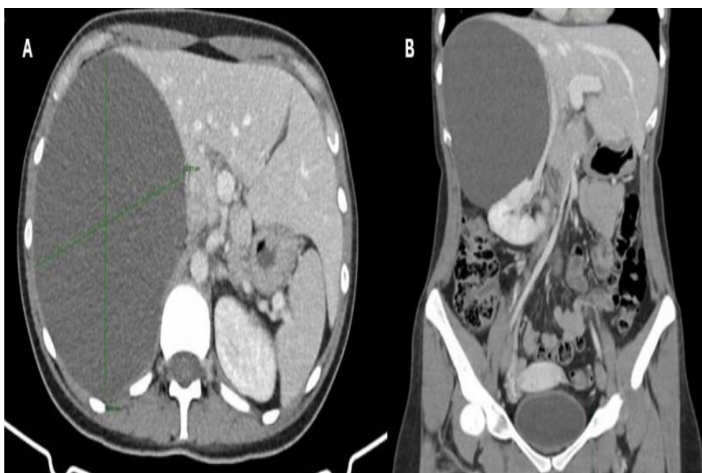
Abdominal CT scan showing a well-defined lesion in the right hepatic lobe, measuring 17x15.7x12cm (LxAPxT) (A) that displaces the right kidney medially and inferiorly (B).
